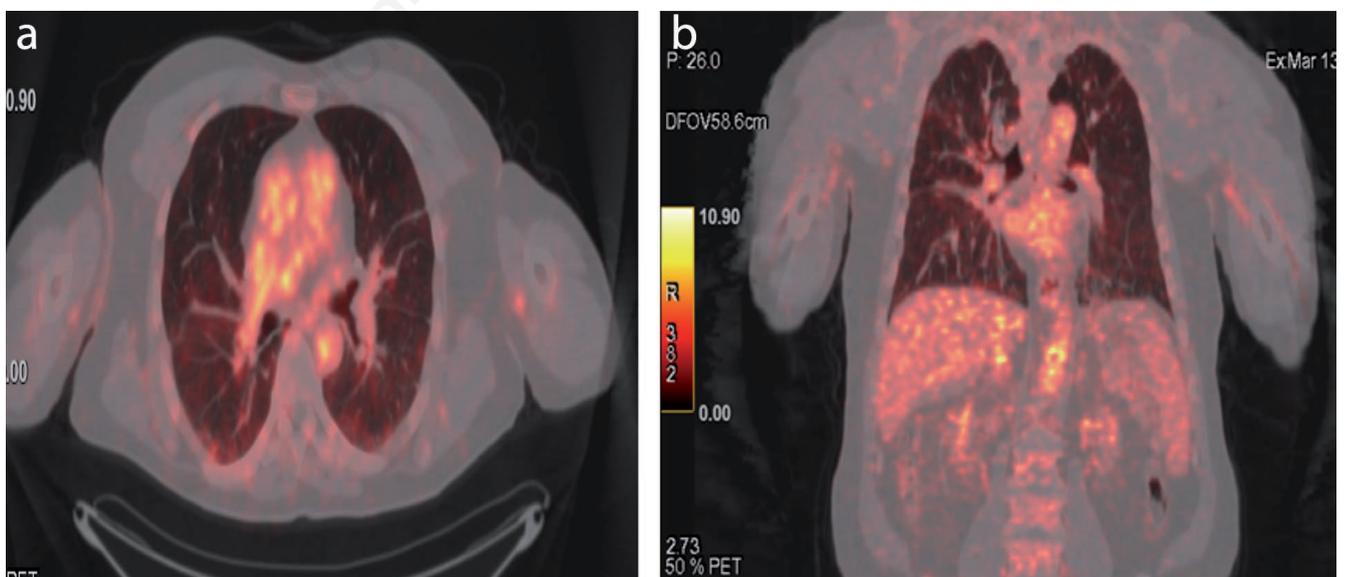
Axial (a) and coronal (b) ^{68}Ga -citrate PET/CT) fusion image showing no active inflammation associated with sarcoidosis disease in the lung and mediastinum.
